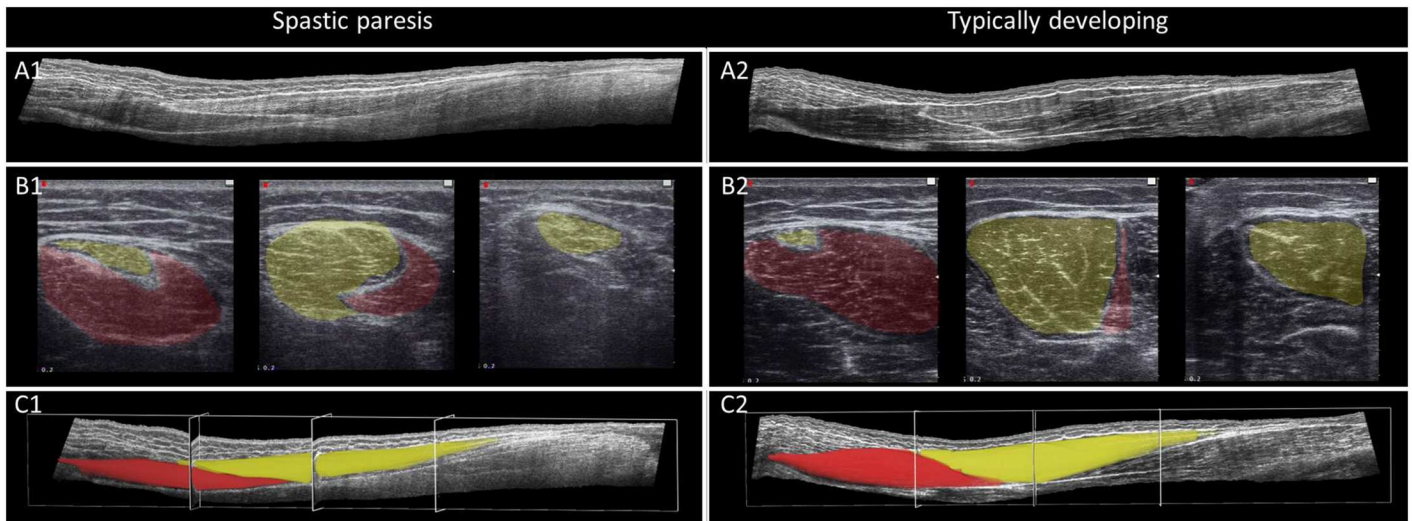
Typical example of 3D ultrasound images and segmentation of muscle volume of a child with a spastic paresis (left A1-C1) and typically developing child (right A2-C2). A: longitudinal view of semitendinosus muscle (ST) (proximal on the left side); B: transversal view of ST at three locations (most proximal on left side; orientation of images: medial (left), lateral (right)); yellow: distal compartment of ST; red: proximal compartment of ST; C: Proximal (red) and distal (yellow) compartments after segmentation.
